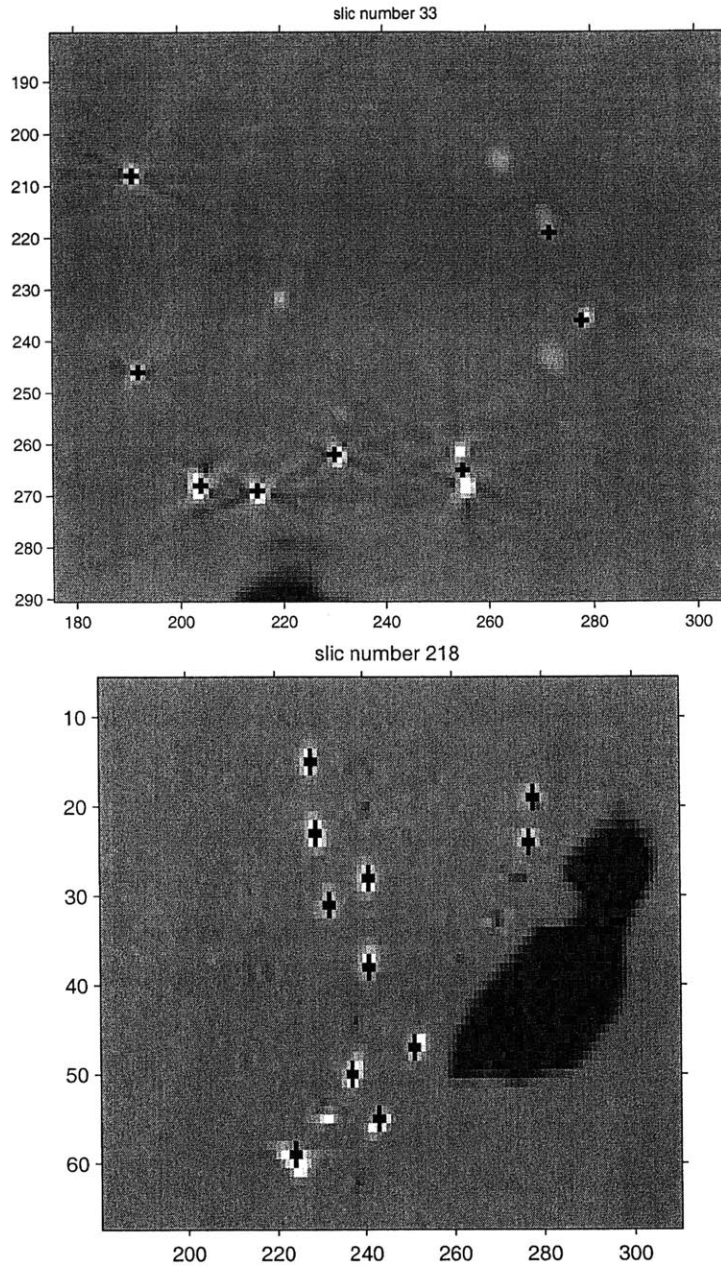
Seeds detected in CT volume, overlaid on the CT image in an axial (top) and sagittal (bottom) view. At their centers, seeds appear as bright white spots in the CT image. Black crosses are overlaid at the centroids of semi-automatically detected seeds. Some smaller or duller spots appear in the axial view. These are seeds whose centers are in the preceding or following slices, and are detected in those slices (not shown). Some dark spots appear in the roughly linear seed patterns in the sagittal view. These are artifacts which surround the bright white seed spots. The artifacts can be seen in the axial view. One pair of seeds in the axial view can be seen to have produced a single detected candidate seed. Corrections for this error are addressed in Section 3.6
